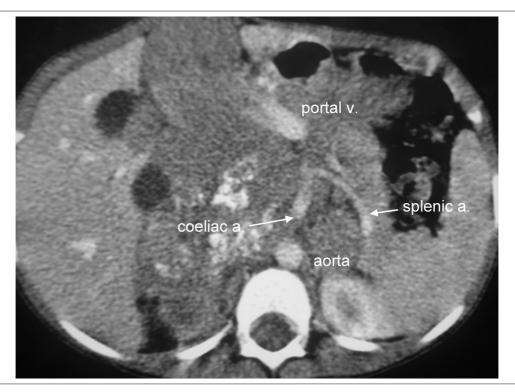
Pre-treatment CT scan of abdominal neuroblastoma.
